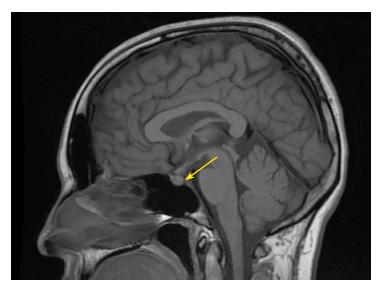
Non-contrast MRI of the head, T1 WI, sagittal projection. Posterior pituitary is not differentiated (changes indicated by arrow).
